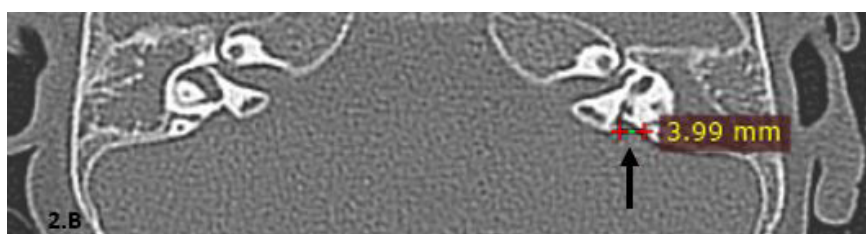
B: Axial CT, bone window view revealed a dilated vestibular aqueduct on the left side (black arrow). Normal diameter less than 1.5 mm.
